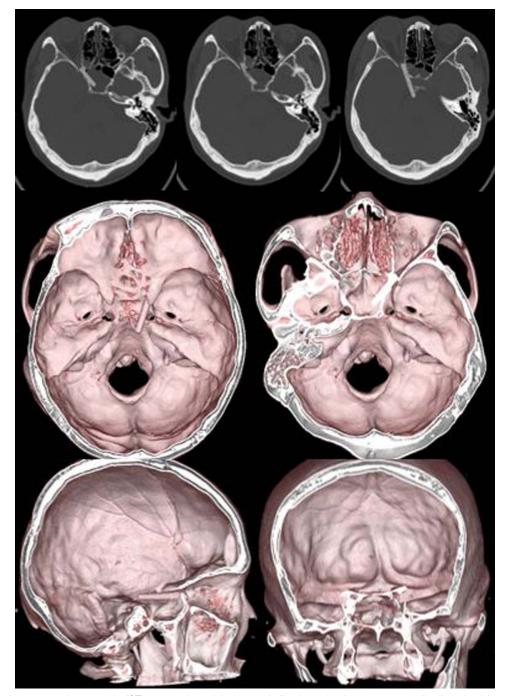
A non-contrast computed tomography (CT) scanner showed the image of a liner hyperdensity structure extending from the right superior orbital fissure (SOF), that's suggesting a foreign body. From a CT scan with 3-dimensional reconstruction, we were able to observe two foreign bodies: the first is through the sphenoid sinus and the second is through the cavernous sinus and terminal at the posterior fossa.
